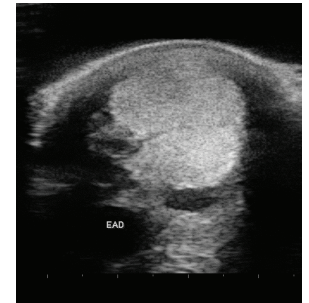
Ultrasound image of the front right limb after 8 sessions of INDIBA®
